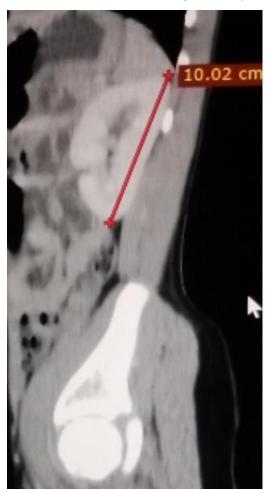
is a sagittal reformats contrast enhanced computed tomography showing the left kidney with its bipolar length measurement.
